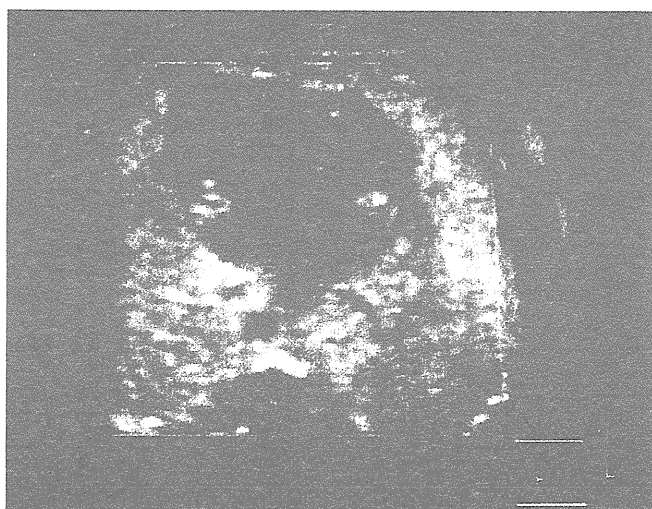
Three-dimensional echocardiography in a case with common atrioventricular valve (asplenic syndrome). Optimal 2D cutting plane can be created from the 3D data set and demonstrated from optimal angle
